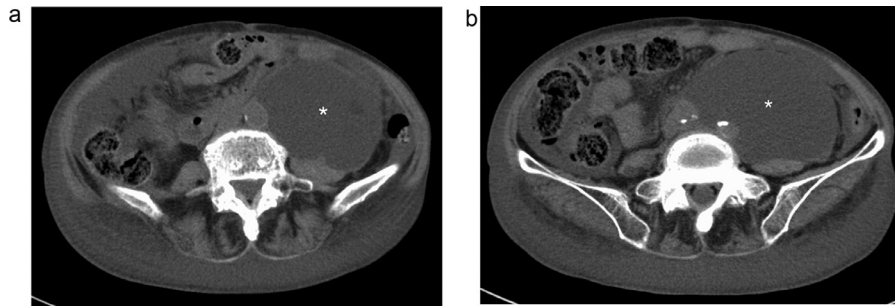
CT examination revealed large amount of fluid in extensive contact with the aorta in the retroperitoneal space (asterisk).
